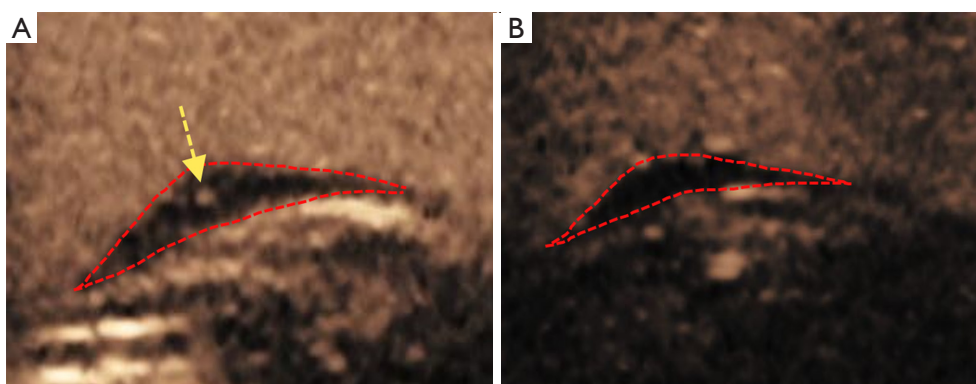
Carotid IPN regression on CEUS. A 37-year-old male patient had IPN grade 1 of the right internal carotid artery as detected on CEUS at baseline. (A) After 1 year of regular moderate-intensity statin therapy, the neovascularization of the same carotid plaque regressed to IPN grade 0 (B). The red dotted lines indicate the carotid plaque, and the yellow arrow indicates the intraplaque contrast microbubbles. IPN, intraplaque neovascularization; CEUS, contrast-enhanced ultrasound.
